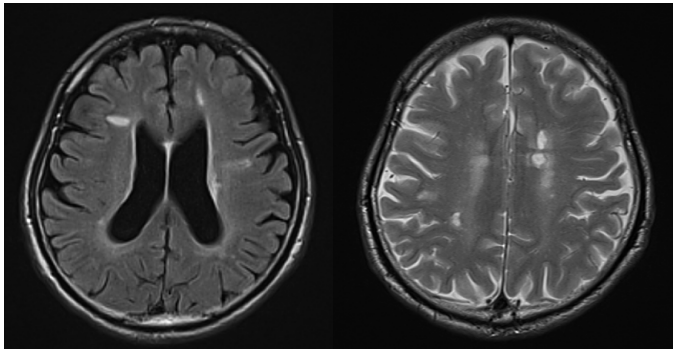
MRI revealed that the vicinity of the right ventricle is high (flair image : left). Right picture is T1WI. Old multiple lacunar infarction was observed.
